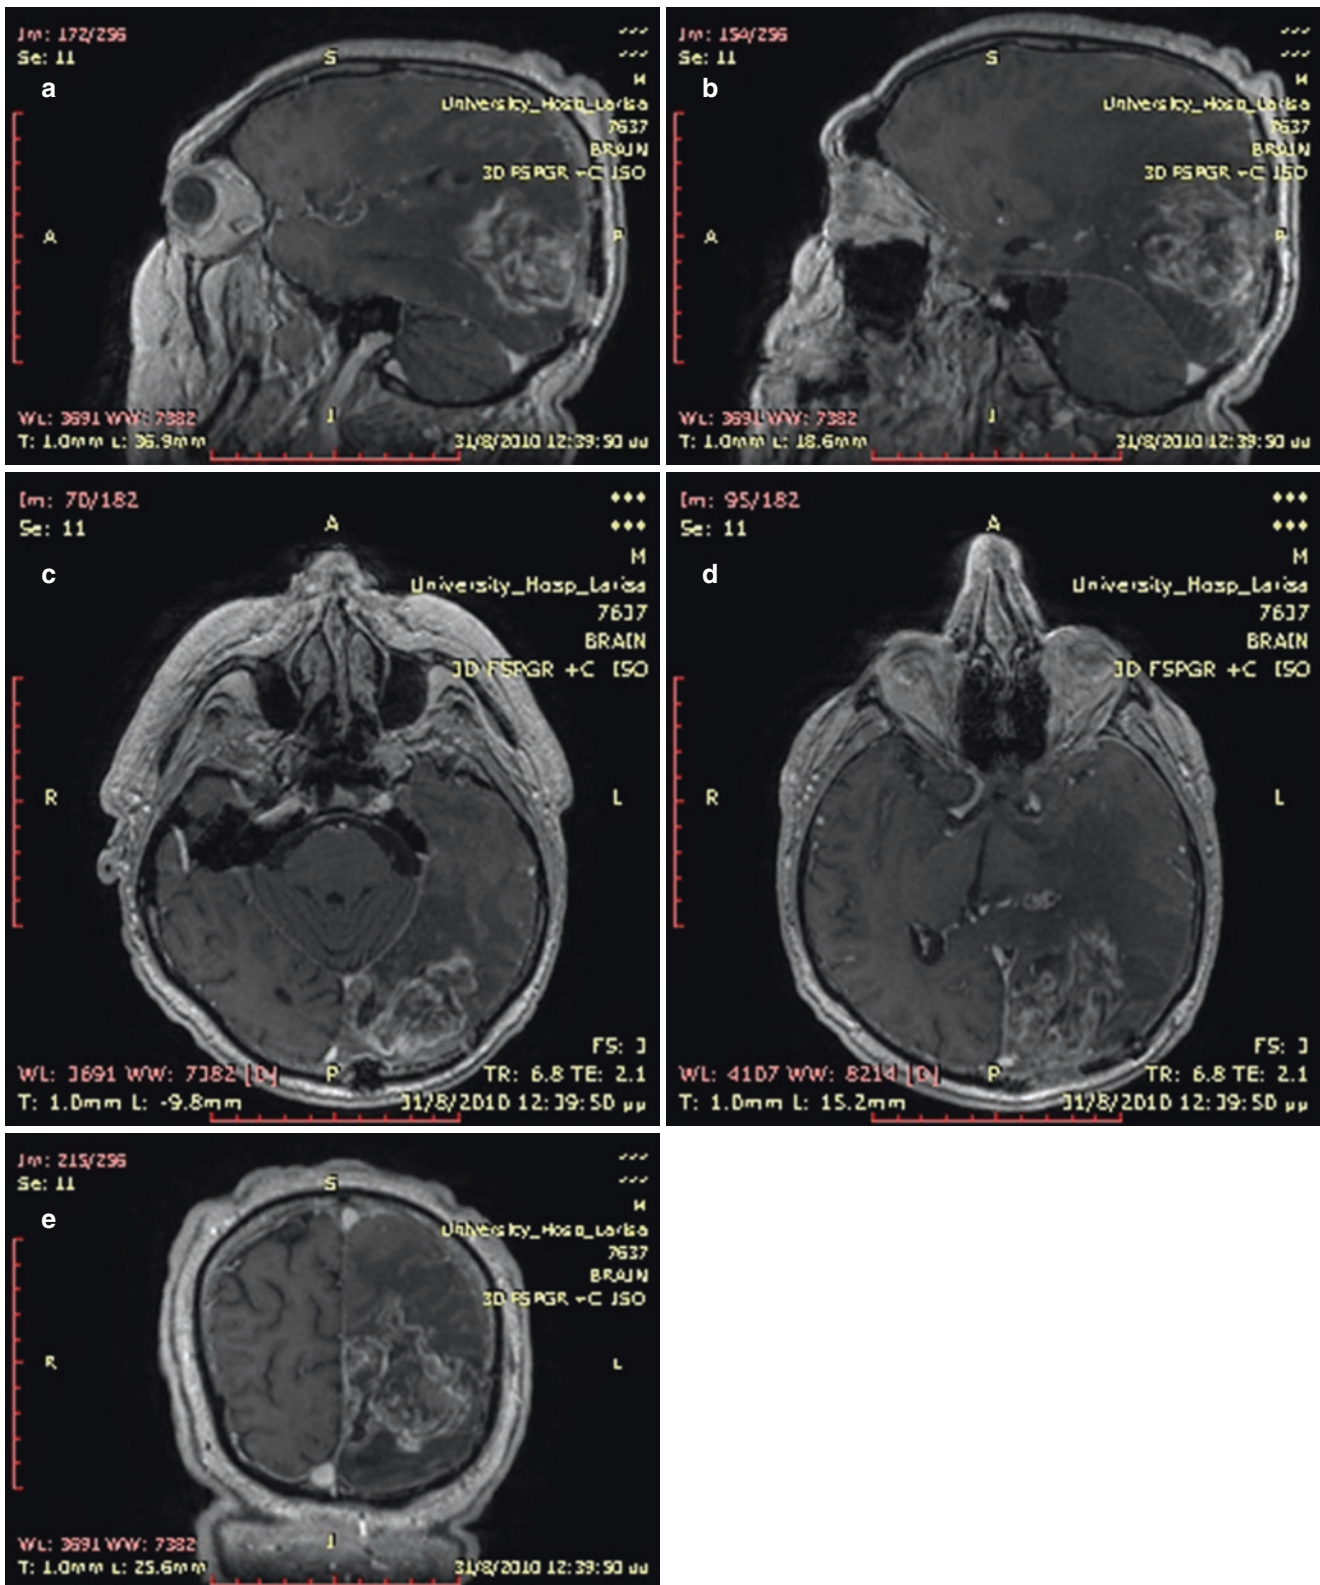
Conventional T1-weighted, sagittal (a, b), axial (c, d), and coronal (e) images after contrast administration demonstrating a large glioblastoma multiforme (GBM) of the left occipital lobe with surrounding edema and necrotic characteristics
